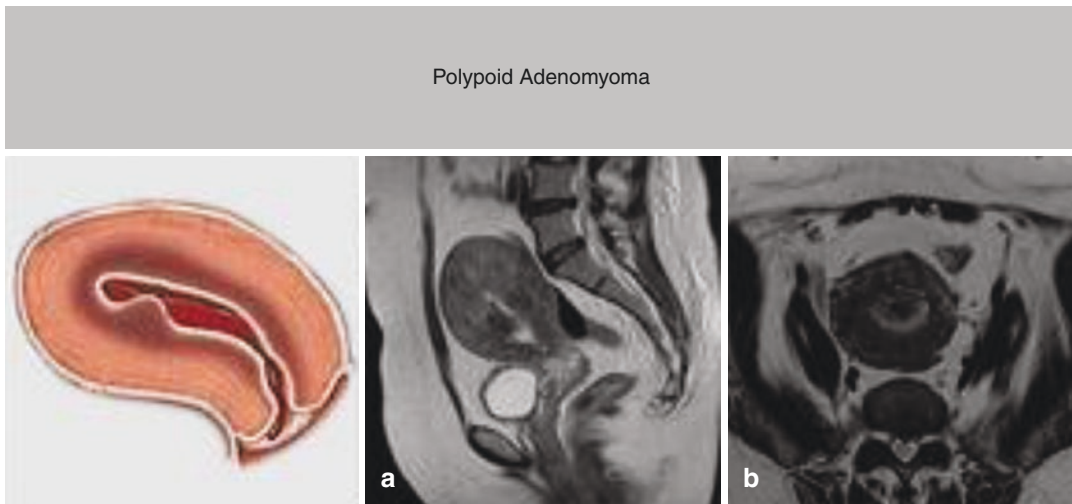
Pictorial presentation and MRI findings of polypoid adenomyoma. (Courtesy: Practical Endoscopy Tips by Expets, Dr. Sunita Tandulwadkar)
